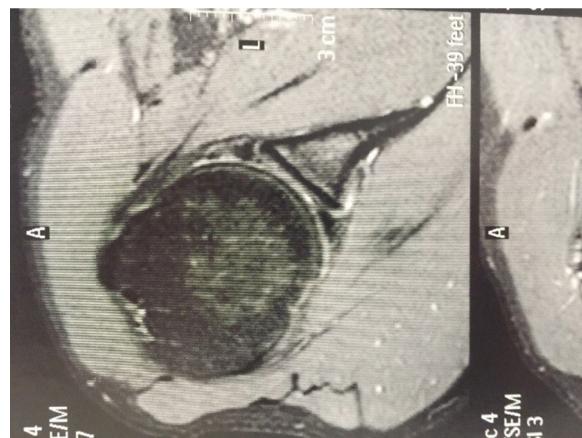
Magnetic resonance image showing anterior and posterior labral injury.
